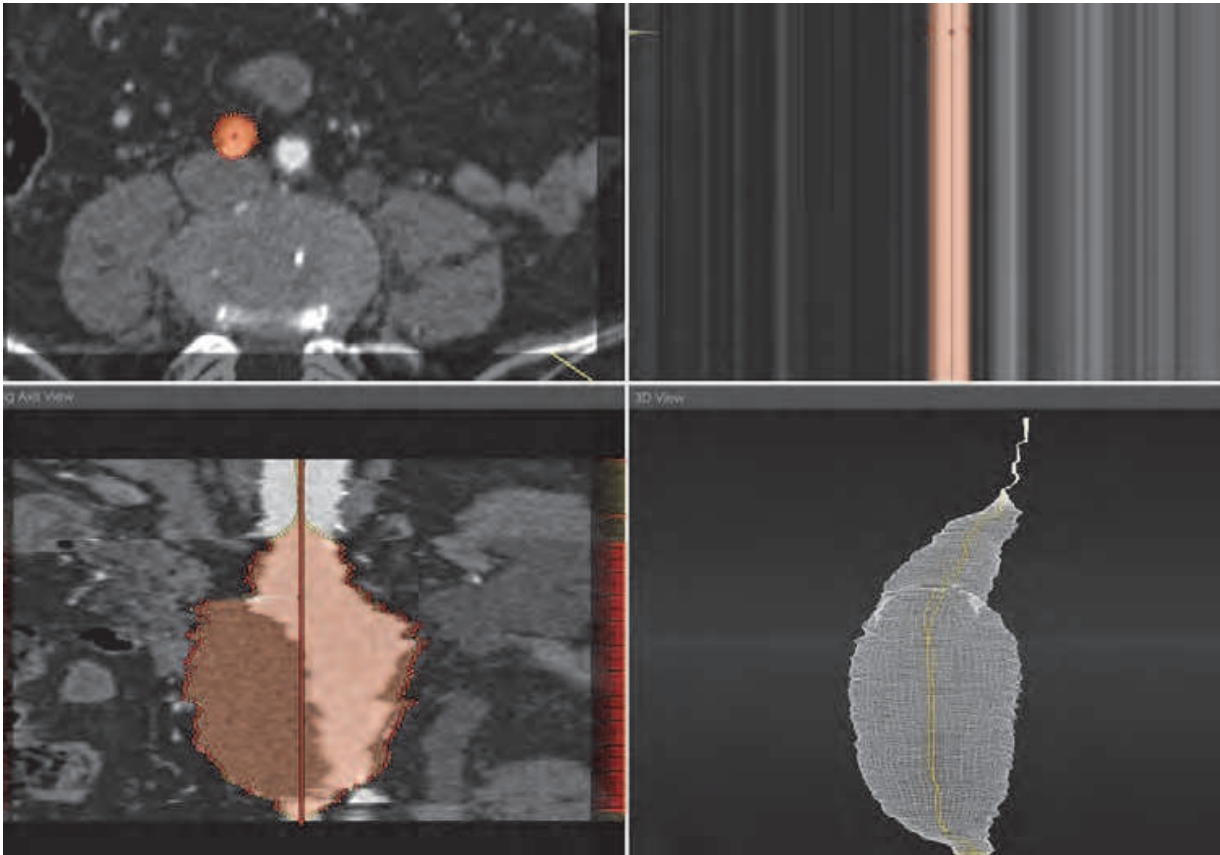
Reconstructed images of the aneurysm are created from contrast enhanced CT images using purpose-developed software.
